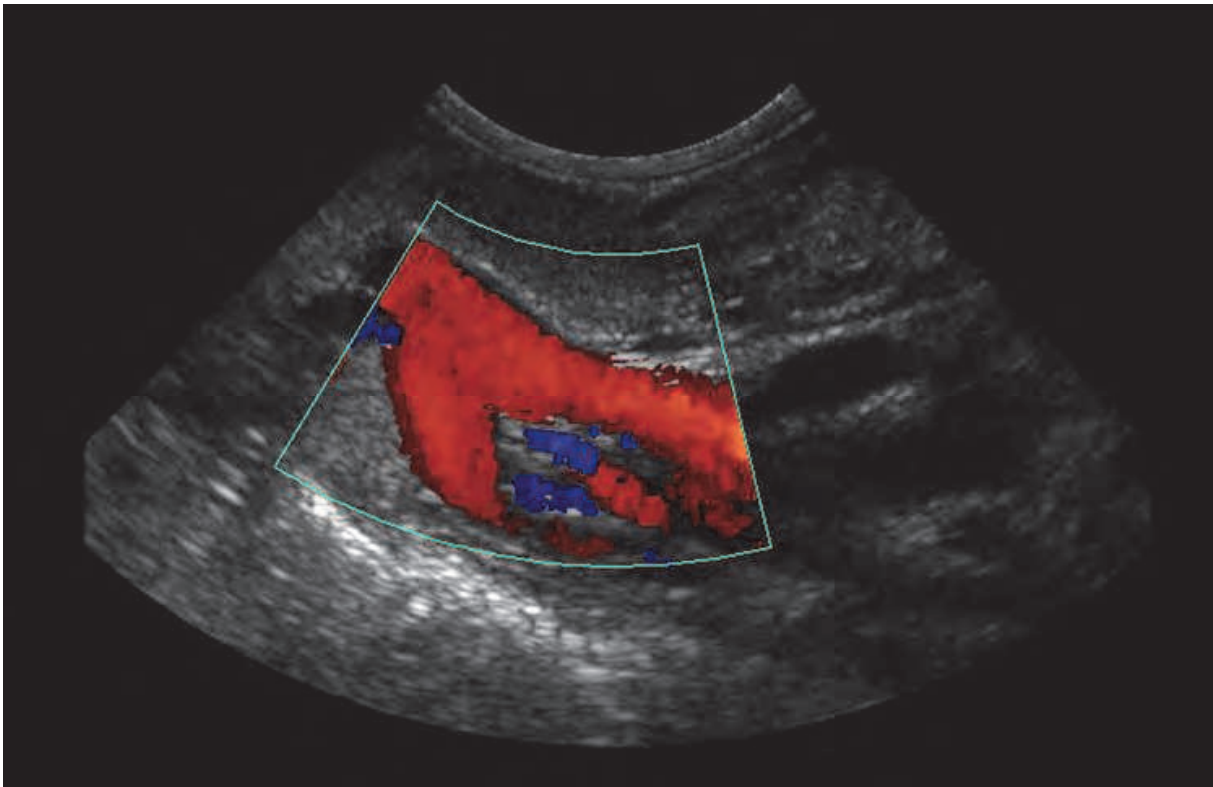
Color Doppler window depicting the mesenteric veins.
